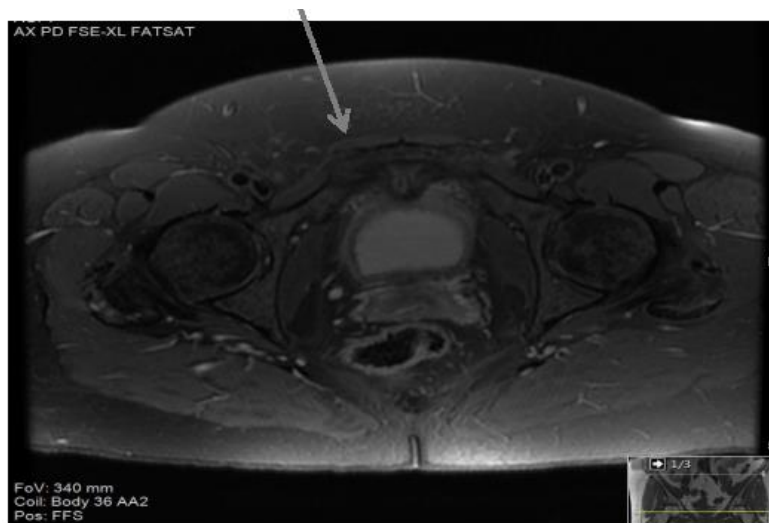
Area showing resolution of osteomyelitis on the right pubic symphysis (on FAT SAT MRI sequence).
